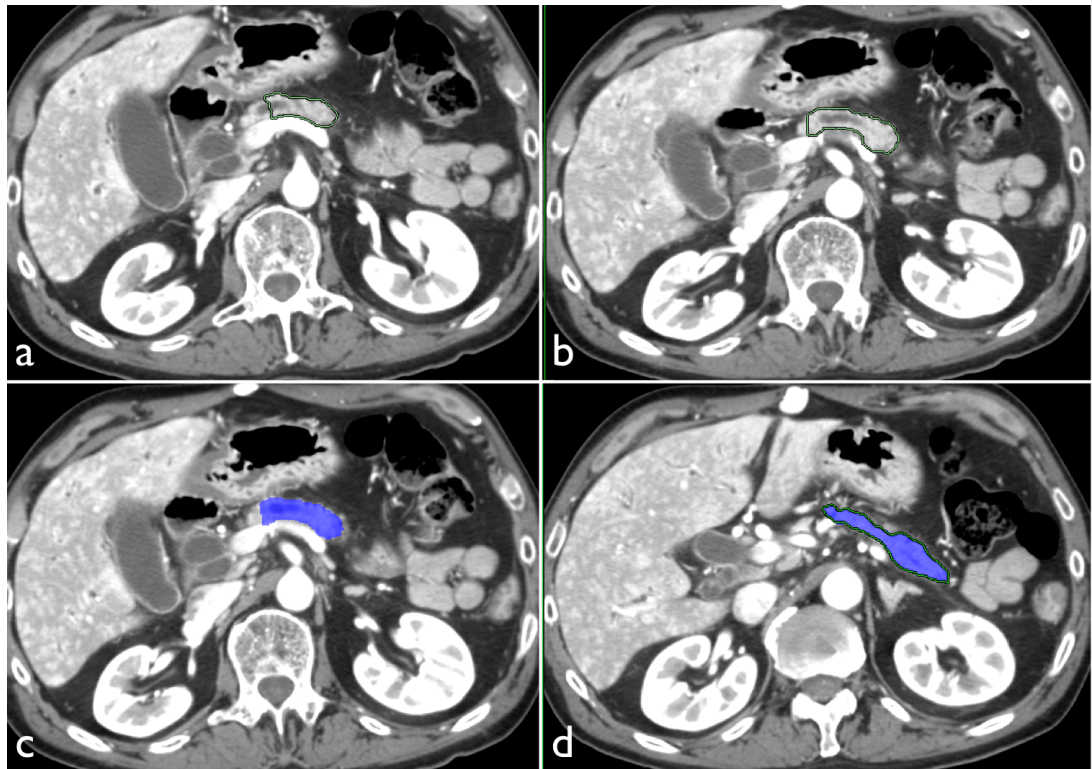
Measurement of PRV of body and tail of the pancreas in Study IV. A preoperative CT examination of the pancreas to measure the volume of the pancreatic remnant after a pancreaticoduodenectomy. Using a semiautomatic segmentation technique, the pancreas can be delineated (green line) first at the level of the alleged resection line (a) and then several sections towards the tail (b). The intermediate sections are automatically bordered (blue area) and have to be checked (c) before continuing segmentation of the caudal remnant (d).
